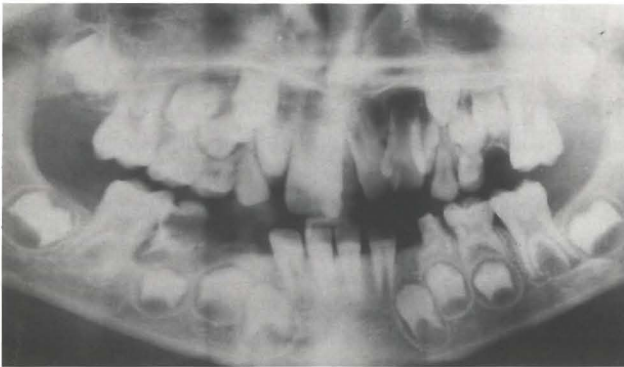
Case 1. Panoramic radiograph showing, in the maxillary right quadrant, a central incisor with a large pulp chamber and root canal. A lateral conoid tooth is adjacent. In the left maxillary quadrant, the two distinct pulp chambers and root canals of the central incisor are evident. The adjacent lateral tooth had a normal morphology. No other anomalies are present.
